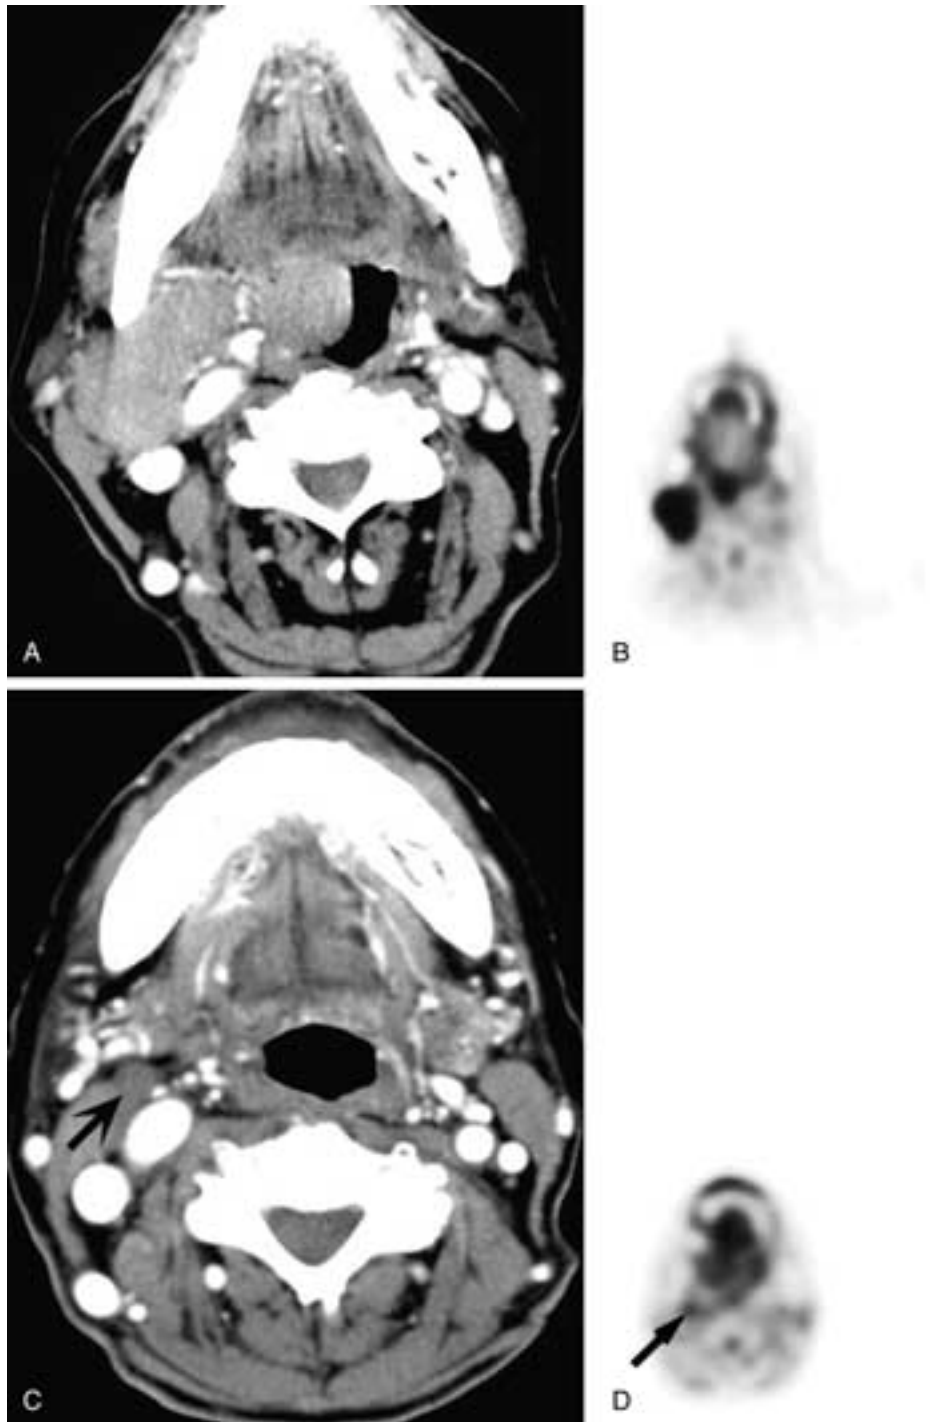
A 65-year-old woman presented with a neck mass that was positive for SCC on fine needle aspiration. Head and neck examination demonstrated a mass in the right tonsillar fossa extending toward the right base of the tongue. A, Contrast-enhanced CT scan shows an exophytic mass emanating from the right tonsillar fossa as well as a large nodal mass. B, An FDG PET scan demonstrates intense uptake in the right tonsil and the right neck mass. The patient was treated with combined radiation therapy and chemotherapy, which she tolerated well. The neck mass resolved clinically, and the tonsillar fossa appeared unremarkable. C, A follow-up CT scan obtained with slightly different angulation shows a normal-appearing right tonsillar fossa but persistent soft tissue in the location of the conglomerate nodal mass (arrow). D, A follow-up FDG PET scan was obtained that showed minimal asymmetry of the tonsils and a small, questionable focus of activity (arrow) at approximately the site of the markedly decreased nodal mass. A neck dissection was performed that showed a focus of tumor only at the level that was suspicious on FDG PET, and the patient has remained well at follow-up.
